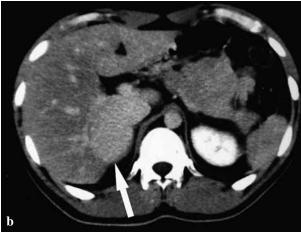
(a) Unenhanced abdominal CT scan shows a hyperdense liver mass (white arrow) at the posterior part of liver segment VI compared to the low-density surrounding liver parenchyma, (b) Post-contrast CT scan at the same level shows homogeneous enhancement of the liver mass (white arrow) compared to lesser enhancement of the surrounding liver parenchyma.
